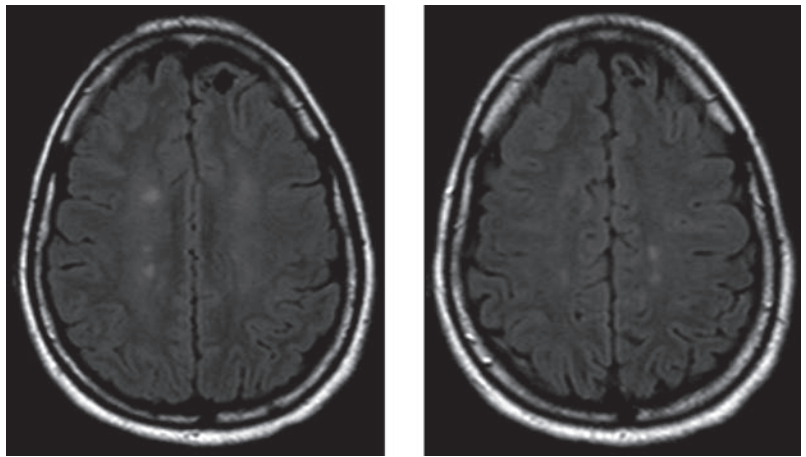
Axial T2-weighted MRI of brain, performed in the month before referral, shows bilateral, hyperintense, white-matter lesions in corona radiata.
